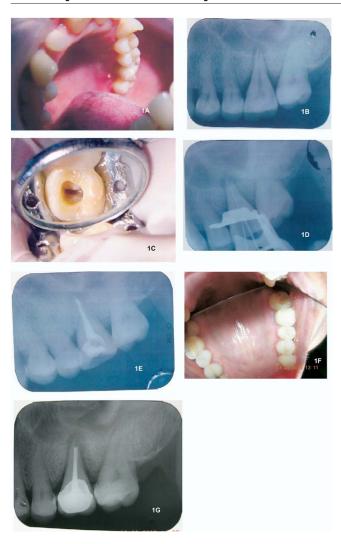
(*A*) Sinus opening in relation to the left maxillary first molar. (*B*) Preoperative Radiograph of the left maxillary first molar. (*C*) Single canal orifice. (*D*) Radiograph with scouting files in position. (*E*) Postobturation radiograph. (*F*) Healing of the sinus opening in relation to the left maxillary first molar. (*G*) Six month follow-up radiograph.
